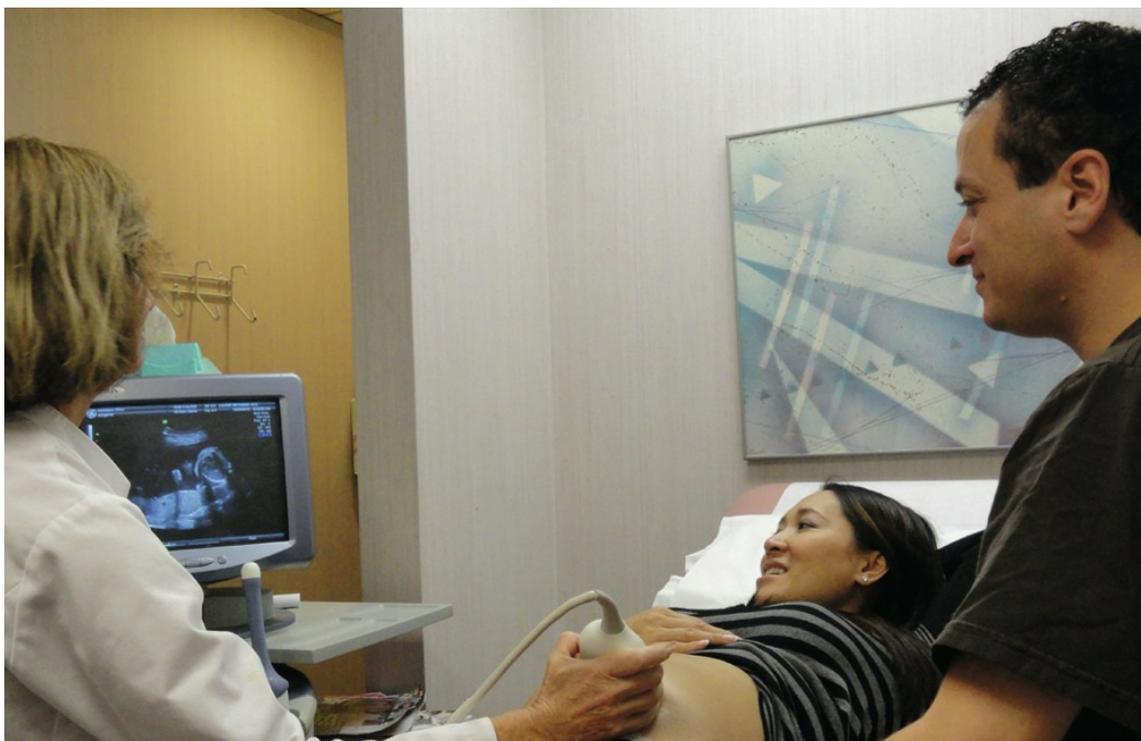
The pregnant woman's family may be present during an ultrasound.
